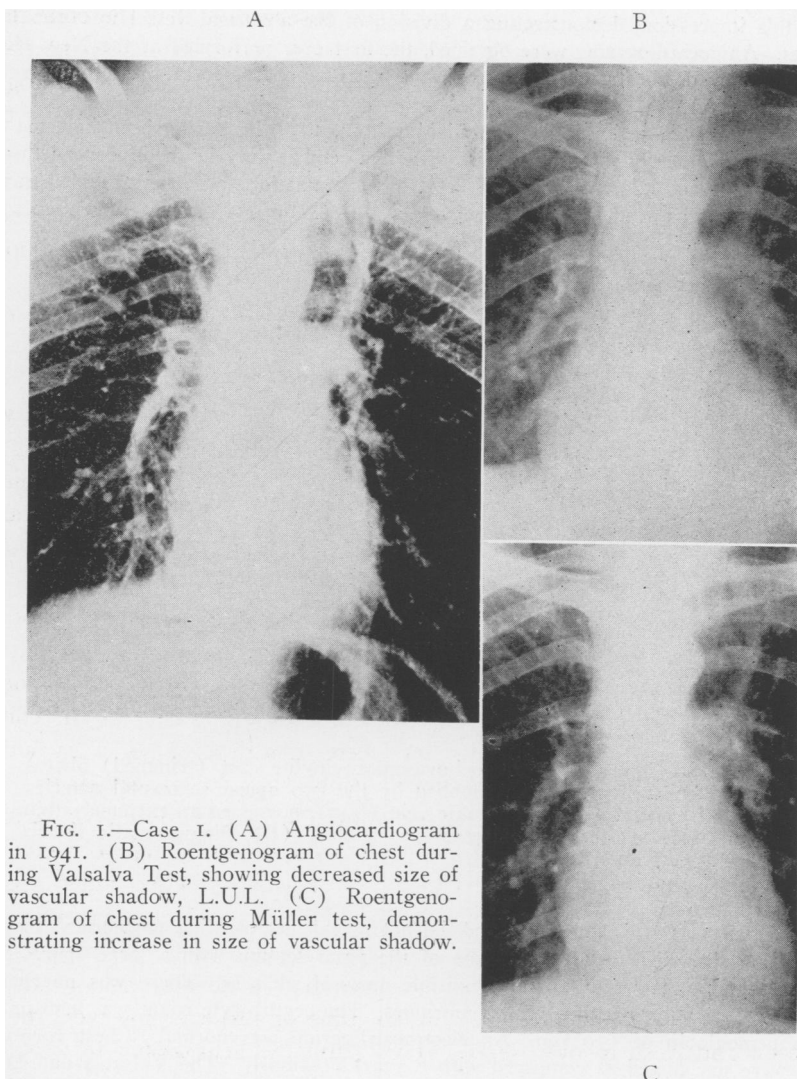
Case 1. (A) Angiocardiogram in 1941. (B) Roentgenogram of chest during Valsalva Test, showing decreased size of vascular shadow, L.U.L. (C) Roentgenogram of chest during Müller test, demonstrating increase in size of vascular shadow.
